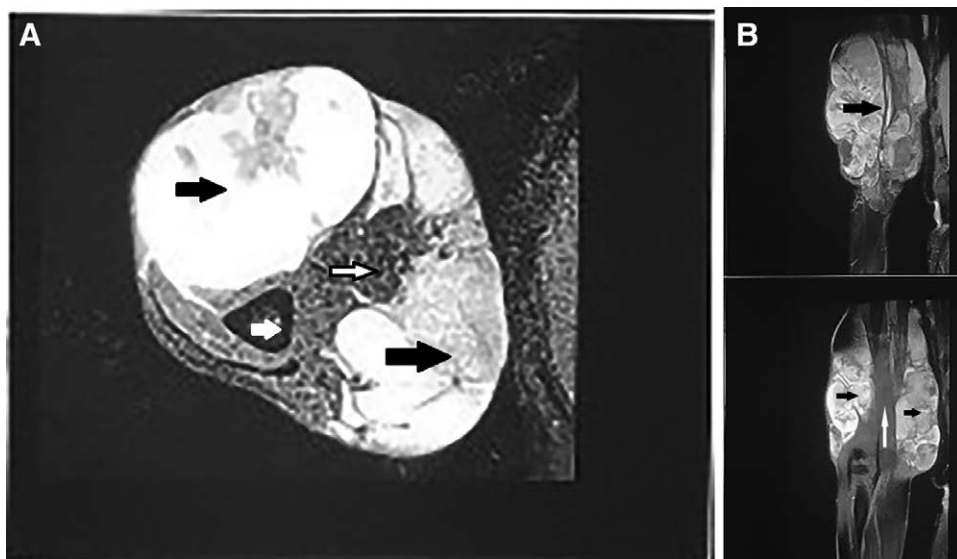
A, Coronal MRI of the arm. Arrows show the humerus (white) and tumor (black). White arrow with black outline is normal muscle compressed by tumor. B, Sagittal cuts through humerus. Arrows show the humerus (white), and tumor (black).
